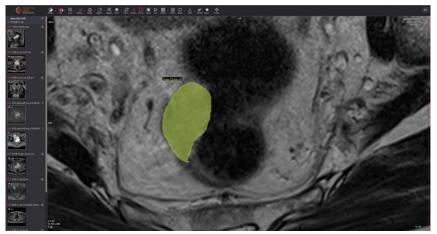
A view from CMRAD annotation model exemplified with a pelvic MRI of a patient with rectal cancer. The green area is the rectal tumour annotated with the Smart Paint 3D tool.
